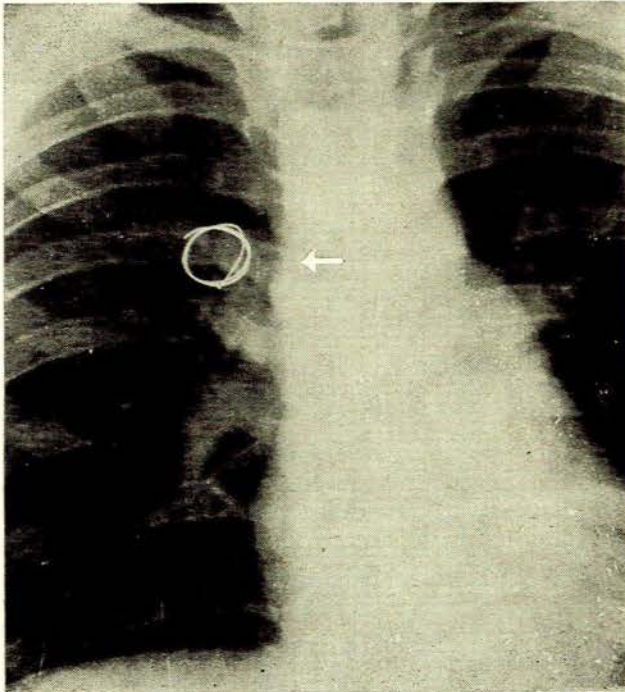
Chest radiograph showing entrance site and pellet in anterior mediastinum.
